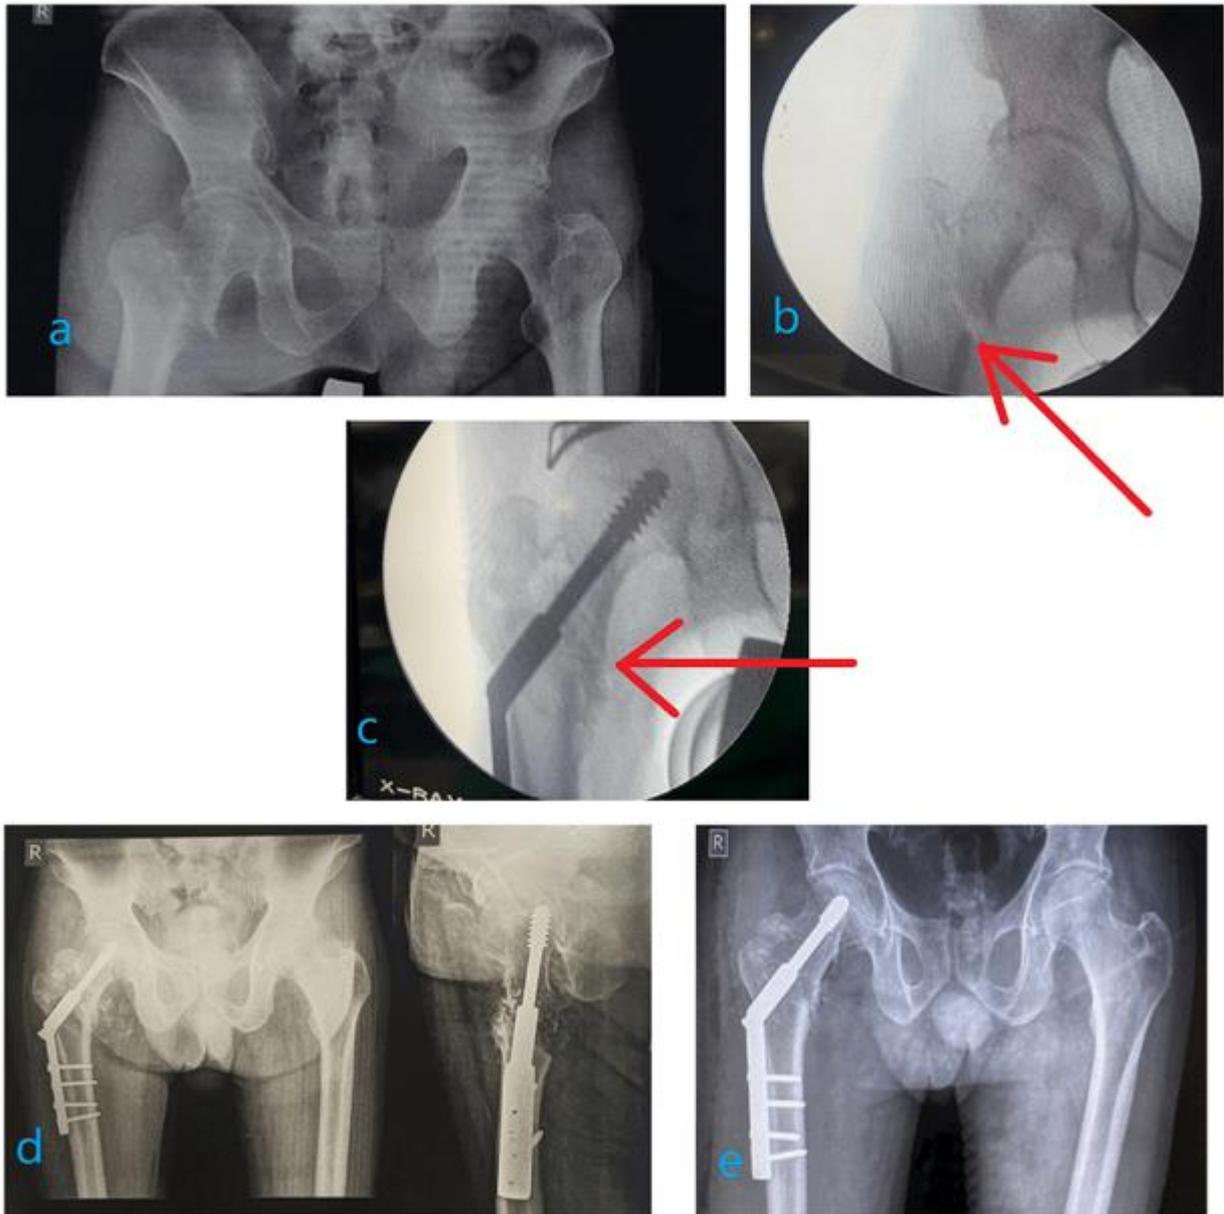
Figure 3(a) shows a pre-operative image of an X-ray of the pelvis with both hips showing a right intertrochanteric fracture; Figure 3(b) is an intraoperative C-arm image of a right, unstable, intertrochanteric fracture after reduction with void space marked by the arrow; Figure 3(c) shows an intraoperative photograph of the right, unstable, intertrochanteric fracture after the insertion of beta-tricalcium phosphate, as observed by the arrow; Figure 3(d) presents a follow-up X-ray of the patient two months post-surgery; and Figure 3(e) shows a follow-up X-ray of the same patient six months post-surgery.
